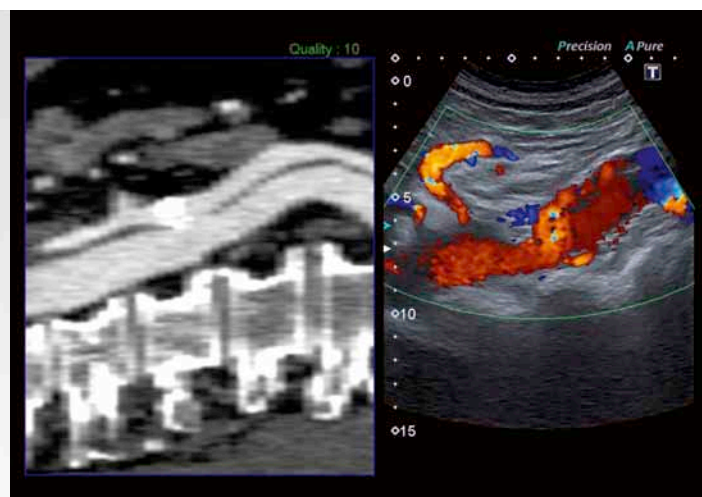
Smart Fusion, color mode: In the color Doppler image, the turbulent flow around the aortic end of the stent can be seen on the right side of the dual screen monitor, the corresponding sagittal plane of the CTA dataset is shown on the left.
